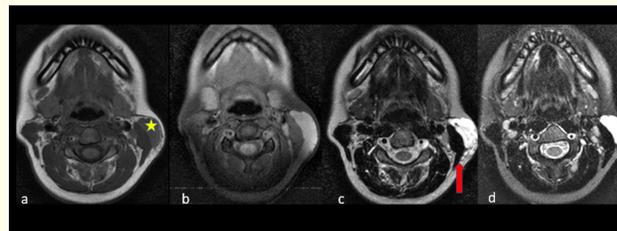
Images from MRI neck at level of oropharynx; a: T1W, b: T1W with fat saturation, c: T2W, d: T2W with fat saturation. A multilobulated lesion within subcutaneous plane of left neck region adjacent to left sternocleidomastoid muscle. Overlying skin is intact.
